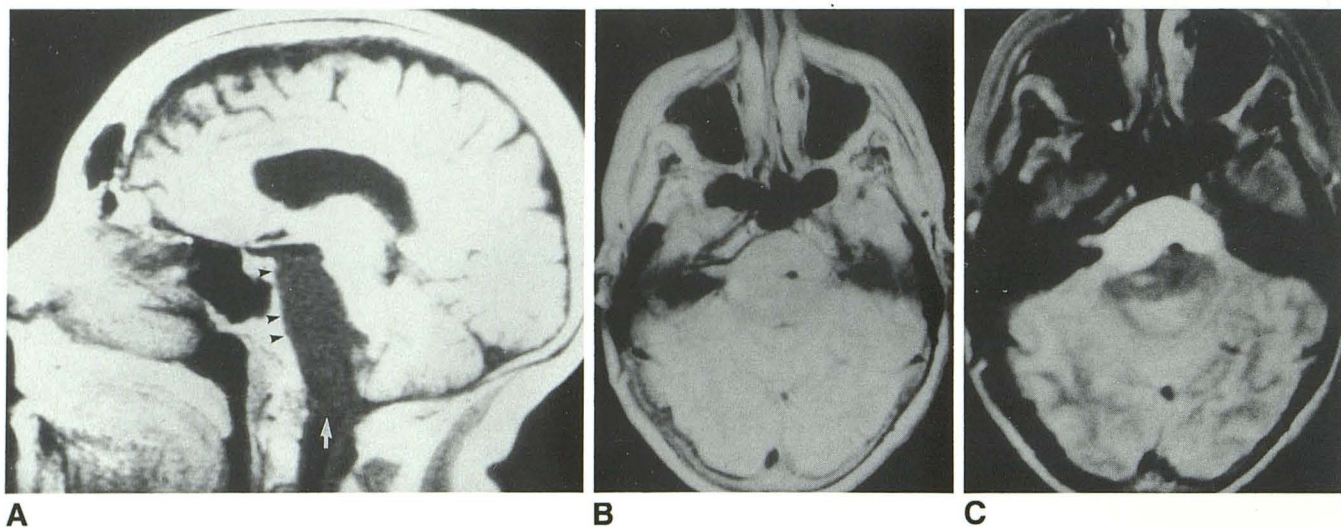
A, Sagittal T1-weighted (390/16/4) image reveals a large, retroclival cyst extending from the posterior suprasellar region to the foramen magnum (arrow), causing compression and posterior displacement of the brain stem and erosion of the dorsum sellae and clivus (arrowheads). B and C, Axial proton-density (1900/40/2) and T2-weighted (1900/95/2) images show the arachnoid cyst compressing the brain stem and extending into the right internal auditory canal. The signal intensity of the cyst is higher than that of CSF because of prior hemorrhage.
